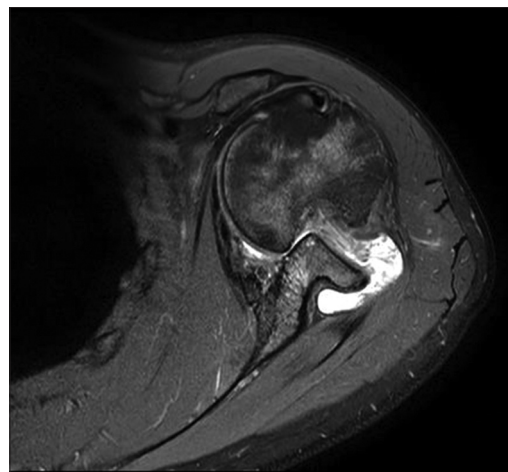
An engaging Hill–Sachs lesion, as seen on T2-weighted MRI image, in a case of chronically locked anterior shoulder dislocation
